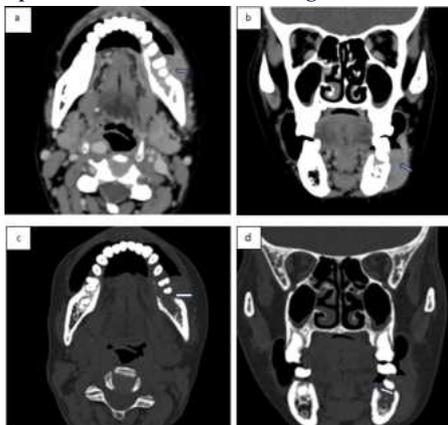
squamous cell carcinoma of gingivobuccal sulcus with bone invasion. (a) Axial and (b) coronal contrast-enhanced CT image (soft-tissue window) demonstrates an enhancing soft-tissue mass (arrows) along the left inferior gingivobuccal sulcus extending to the buccal mucosa. (c) Axial and (d) coronal contrast-enhanced CT image (bone window) shows cortical erosion (arrow) along the left buccal and lingual aspect of the mandibular alveolus.
